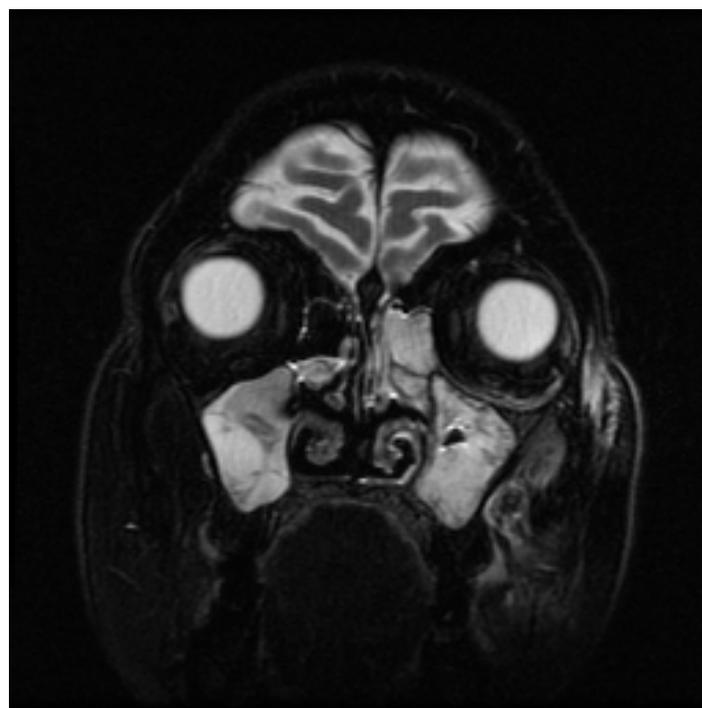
Coronal T2-weighted FSE MRI of patient demonstrating bilateral maxillary and ethmoid sinusitis.
